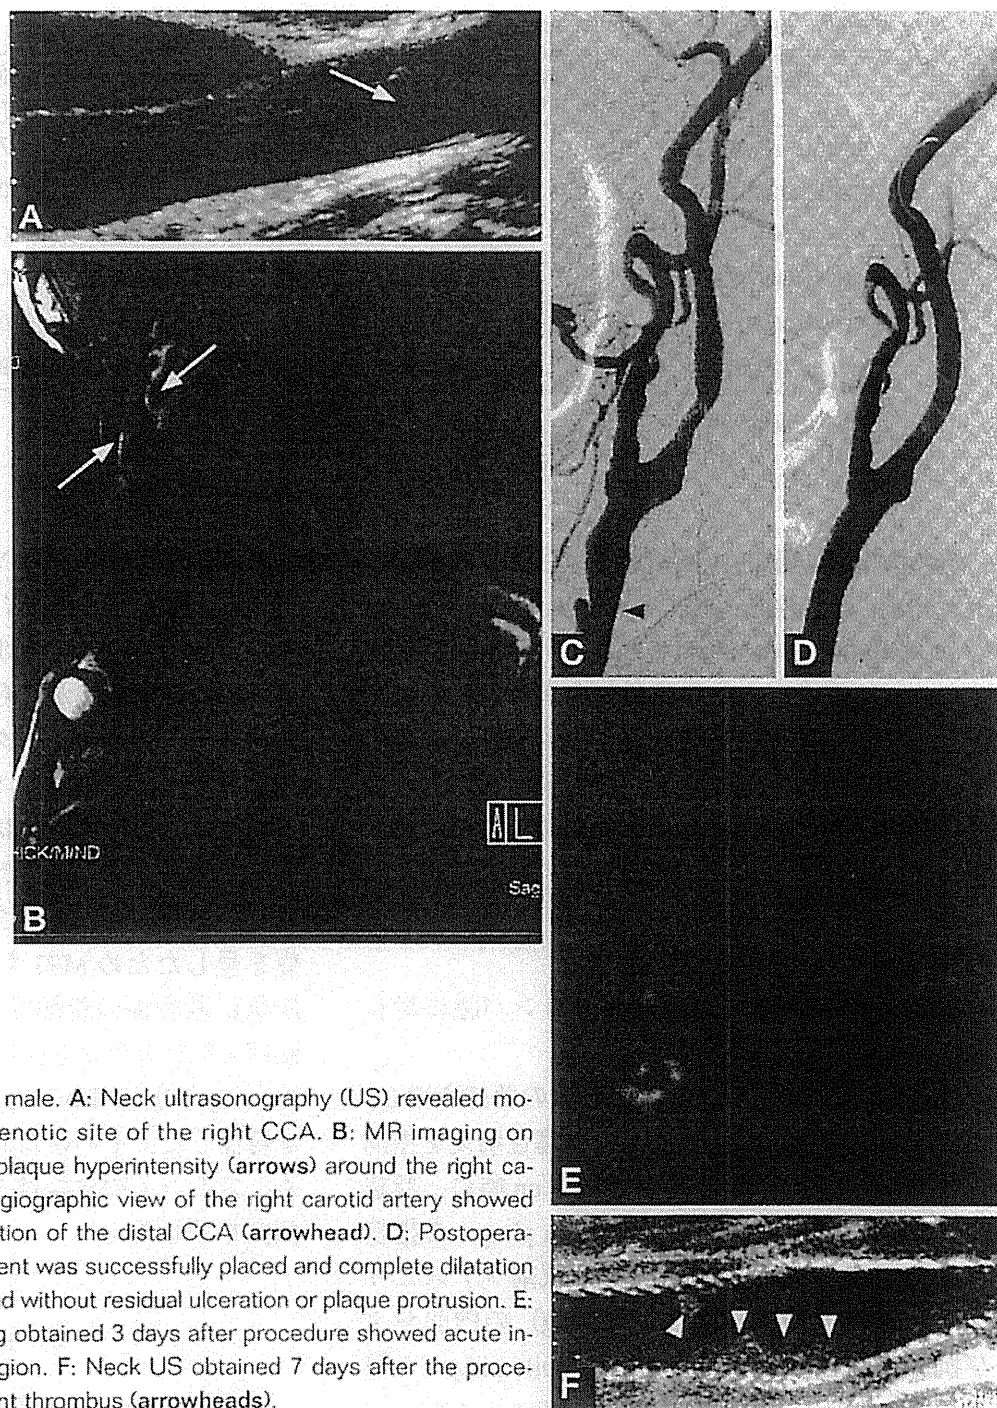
Case 2. A 74-year-old male. A: Neck ultrasonography (US) revealed mobile plaque (arrow) at the stenotic site of the right CCA. B: MR imaging on MPRAGE-sequence revealed plaque hyperintensity (arrows) around the right carotid bifurcation. C: Lateral angiographic view of the right carotid artery showed moderate stenosis with ulceration of the distal CCA (arrowhead). D: Postoperative CCAG showed that the stent was successfully placed and complete dilatation of the stenotic site was obtained without residual ulceration or plaque protrusion. E: Diffusion-weighted MR imaging obtained 3 days after procedure showed acute infarction at the right parietal region. F: Neck US obtained 7 days after the procedure revealed a massive in-stent thrombus (arrowheads).
